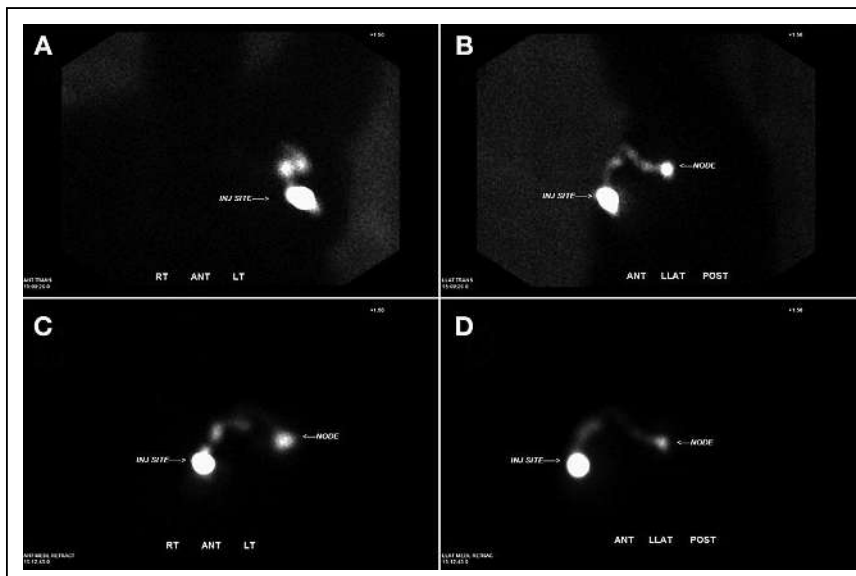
(A) Anterior ^{99m}Tc -tilmanocept lymphoscintigraphy image demonstrates focal areas of increased uptake superior to injection site. Sentinel node is not clearly identified. (B) Lateral image demonstrates lymph channels and sentinel node. (C and D) Repeat anterior (C) and lateral (D) images during medial breast traction demonstrate marked improvement of visualization of lymph channels and sentinel node on anterior view.
